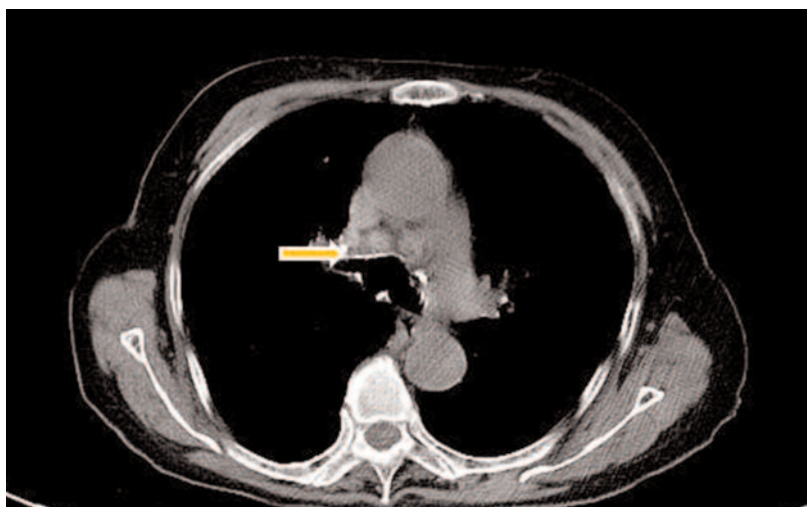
Chest CT scan shows right upper lobe atelectasis in the 39-year old woman with pulmonary tuberculosis.
